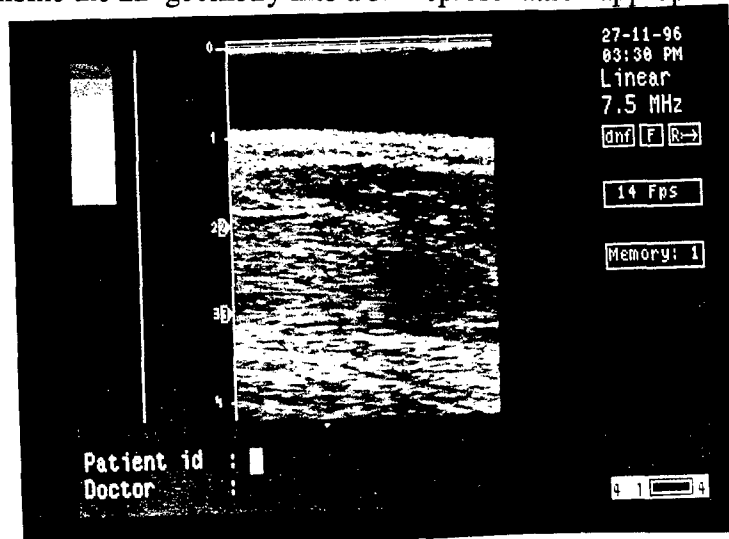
This is a typical image produced by the B-mode ultrasound scanner.
